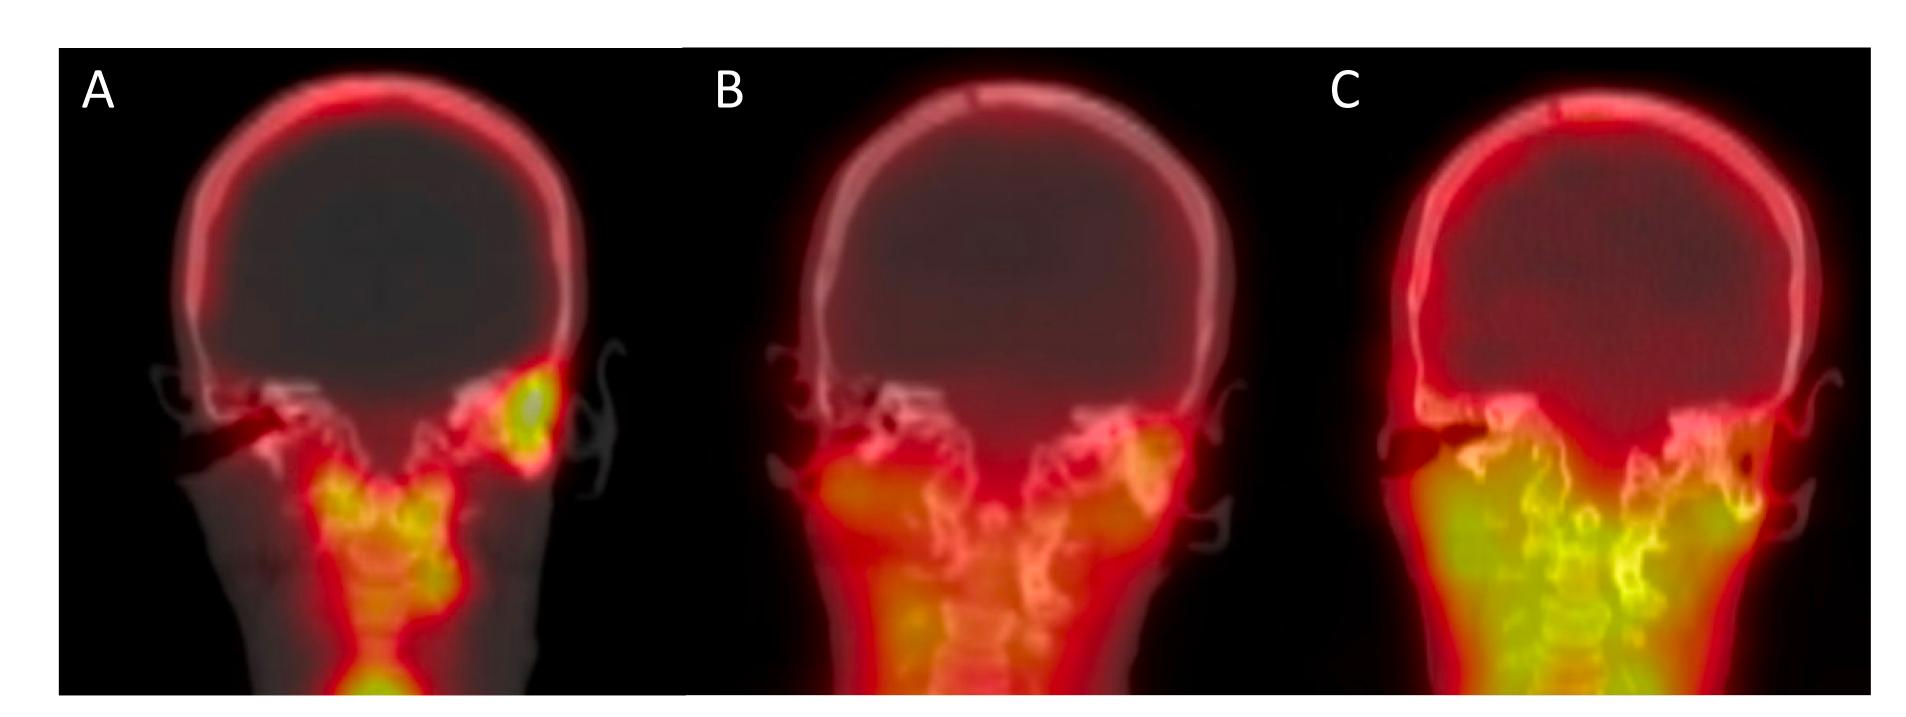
SPECT gallium-67 coronal imaging. A. February, 2021 scan demonstrating asymmetric increased uptake in the left mastoid and along the left skull base. B. July, 2021 scan demonstrating persistent increased activity in the left mastoid after completing a six-week course of IV piperacillin-tazobactam and HBO. C. January, 2023 scan demonstrating no definitive increased uptake in the left or right mastoid or skull base after repeat systemic antibiotic treatment including linezolid and omadacycline.
